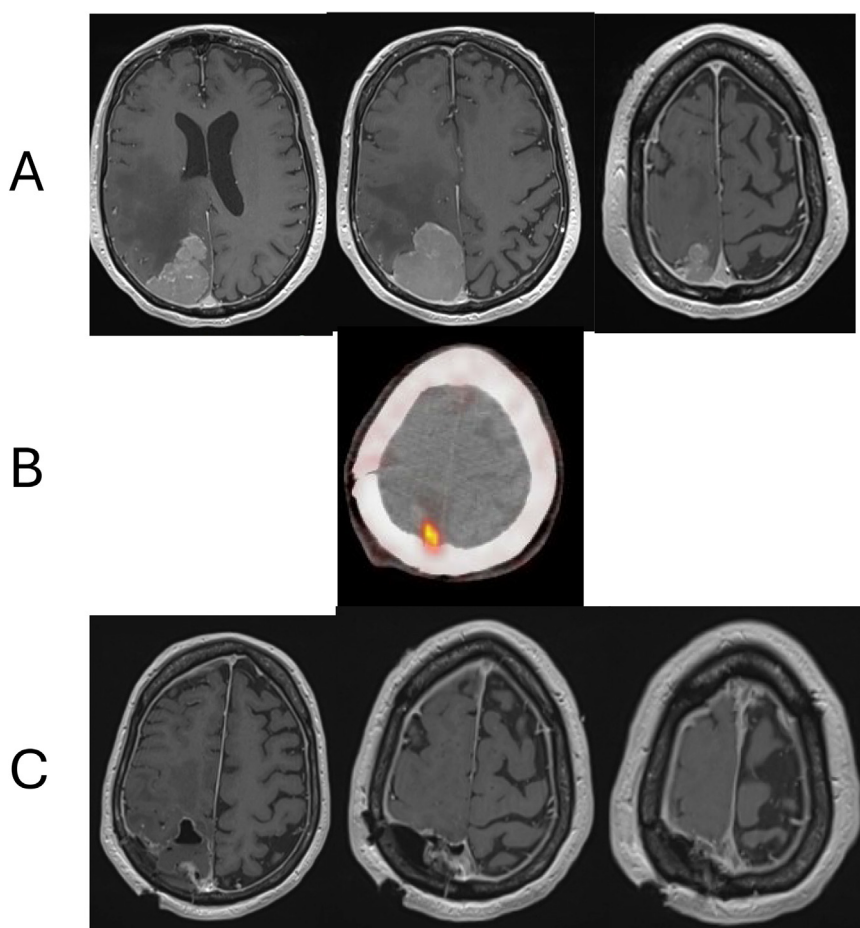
Case 1-Grade 3 meningioma with residual disease on PET. (A) Preoperative MRI. (B) Postoperative PET. (C) Postoperative MRI. *Abbreviations:* MRI = magnetic resonance imaging; PET = positron emission tomography.
